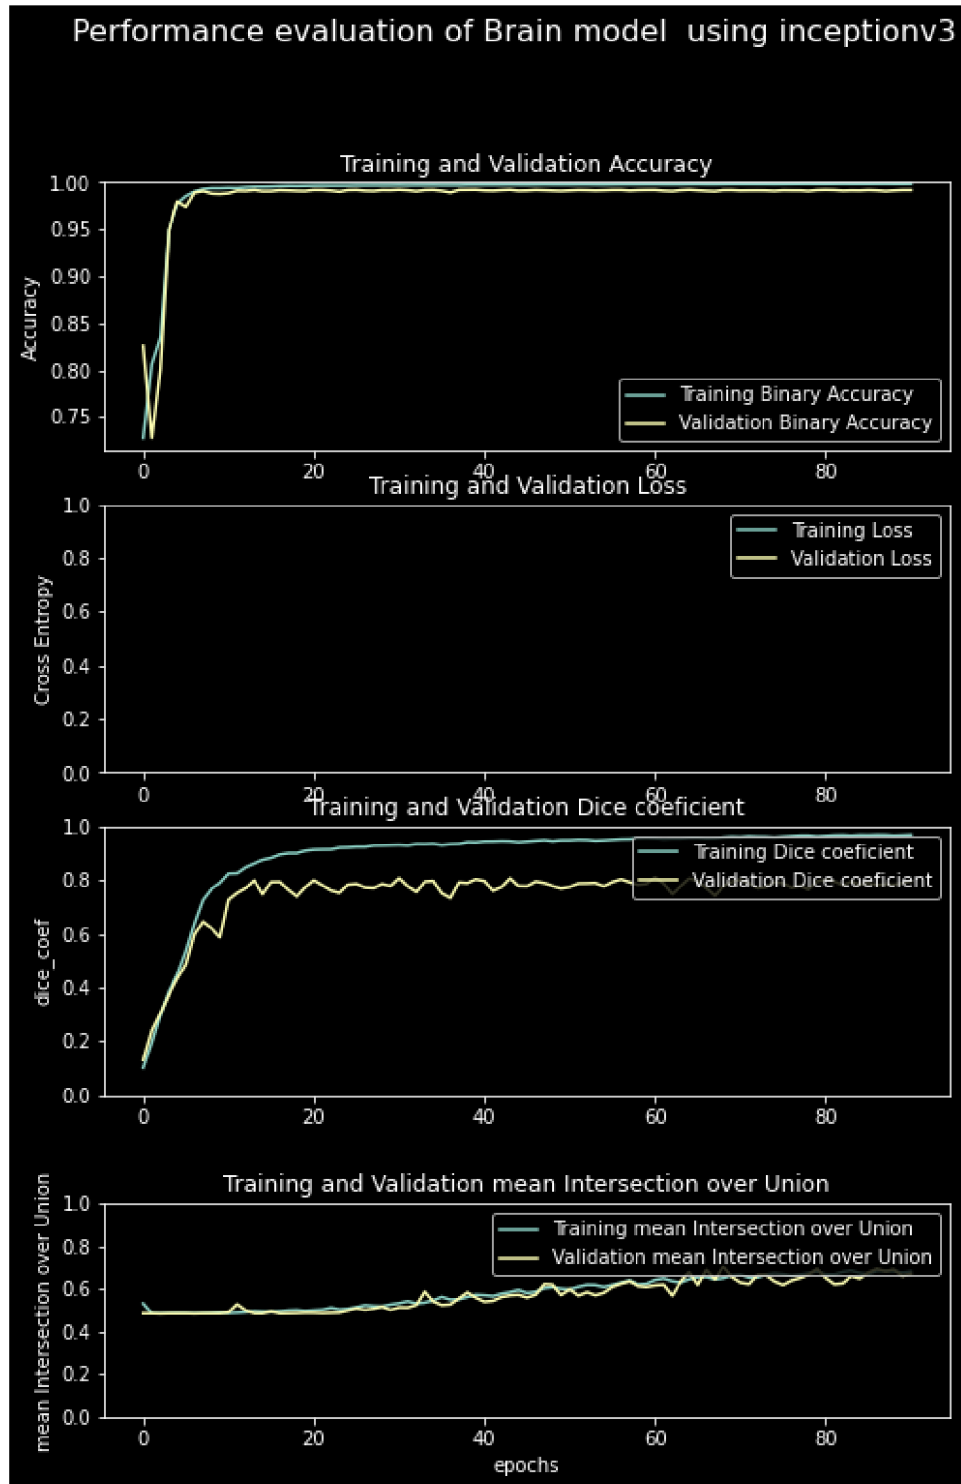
Performance of the custom u-net model using InceptionV3 backbone on Brain MRI images. Note the epoch (abscise) graduation with 1 unit = 20 epochs to show the different intersections of the learning and validation curves due to the gradual change in the learning rate up to 0.0001. (*Own work*)
